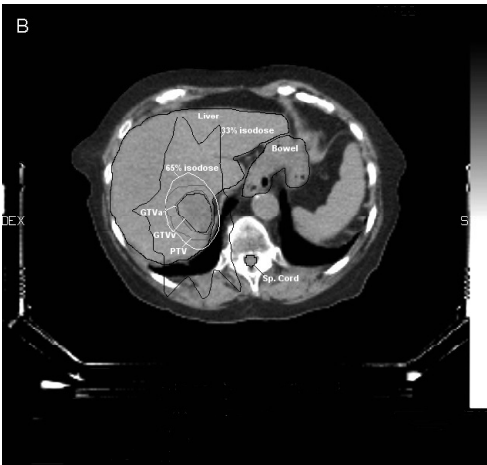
CT-planning showing the delineations corresponding to the two liver metastases in segment 7, both included in one target, the GTV arterial and venous phase, the organs at risk (liver, bowel and spinal cord), the PTV surrounded by the 65% isodose and the 33% isodose.
